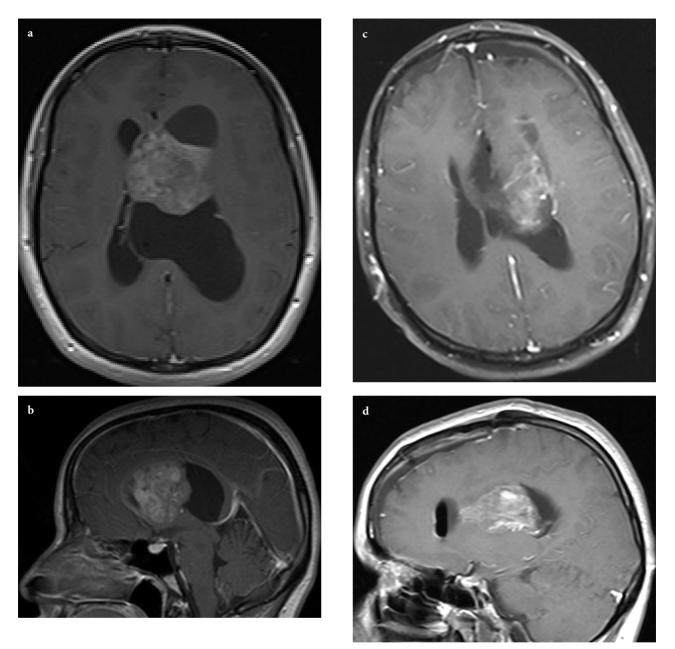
This 26-year-old female (patient no. 16 in the tables) was admitted to our clinic complaining of headache. Contrasted axial (a) and sagittal (b) planes of the head MRI showed heterogeneous mass lesion within the left frontal horn of the lateral ventricle causing massive dilatation of the ventricles. The tumor was mainly located in the atrium and the body. The patient underwent surgery, in which an interhemispheric-transcallosal approach was chosen. After becoming certain that the entire tumor was removed, the surgery was terminated. However, early head axial (c) and sagittal (d) MRI showed a residue on the most lateral part of the ventricle. A second surgery was planned and this time a transcortical approach to the left middle frontal gyrus was performed. The rest of the tumor was removed in toto and head MRI after the second surgery showed no tumor (e and f). The patient was diagnosed with neurocytoma (grade II) and discharged from the hospital without any clinical sequelae. At the last follow-up (28 months after surgery), contrasted head MRI (g and h) showed no residue or recurrence and the patient was doing well without any medications.
